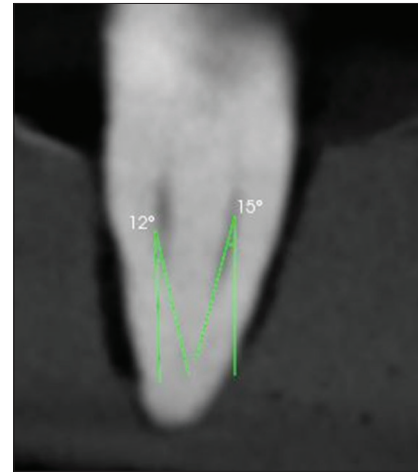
Calculating canal angulation of mesiobuccal and mesiolingual canal using cone-beam computed tomography
